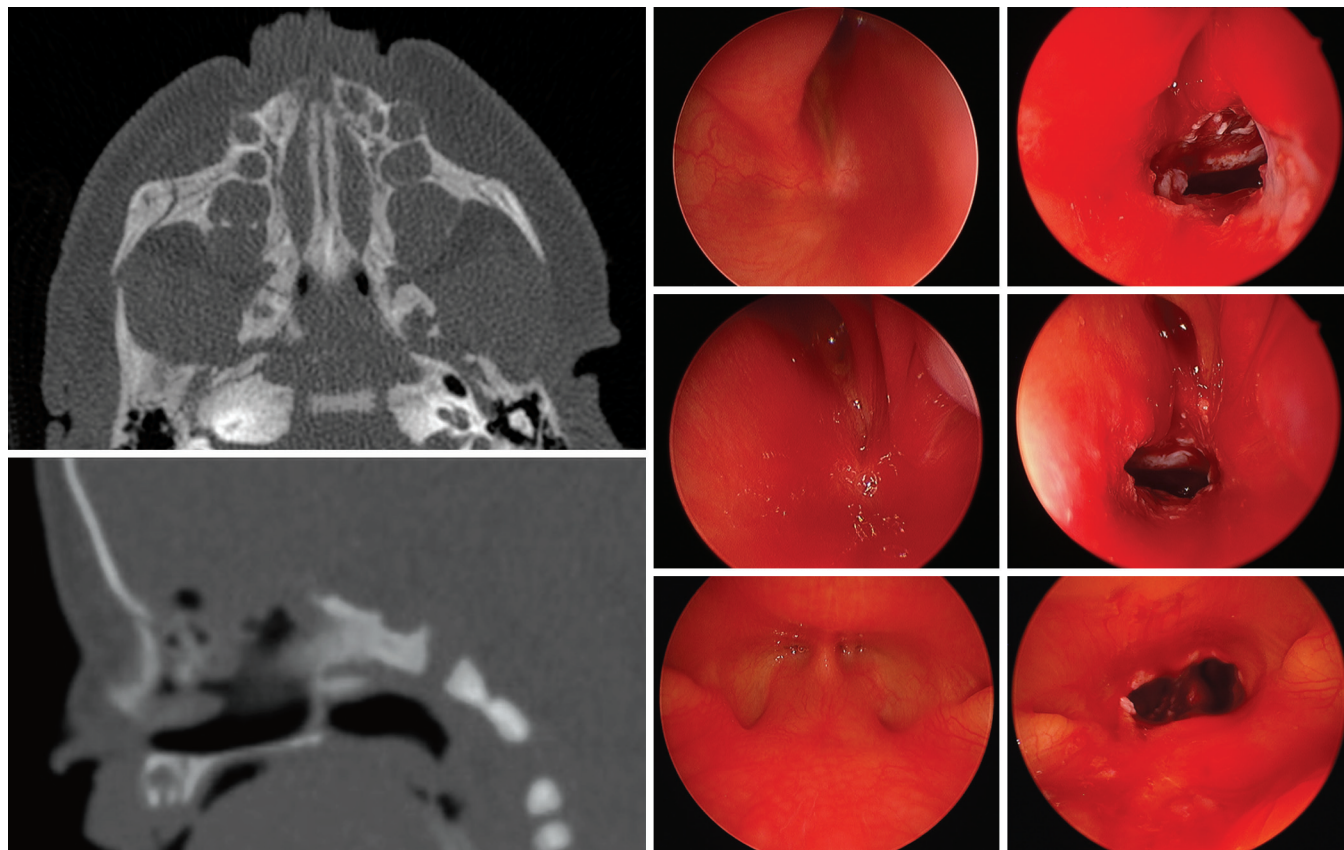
Choanal atresia. Axial (top left) and sagittal (bottom left) CT images demonstrating bilateral choanal atresia. Pre- (middle column) and post- (right column) operative endoscopic images of the right (top) and left (middle) choanae from the nasal cavity, and 120° endoscopic views from the oropharynx showing the nasopharyngeal view of the posterior choanae (bottom) are shown.
